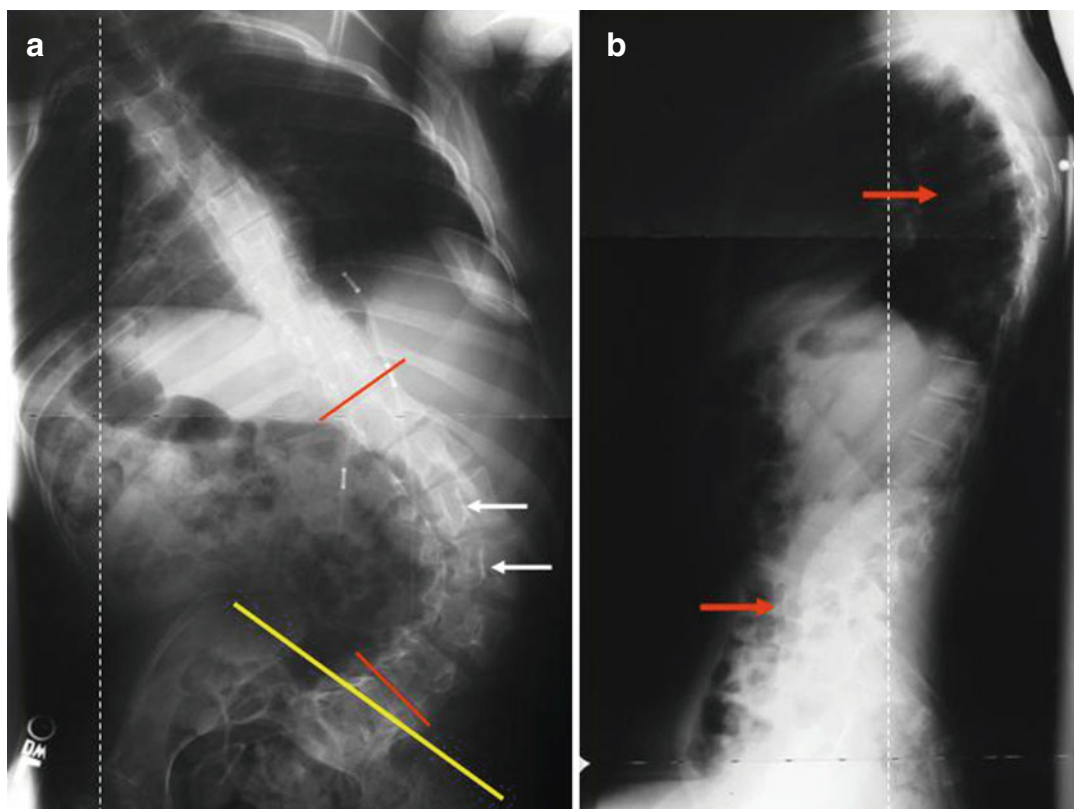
When evaluating a patient with CP scoliosis, there are other radiographic parameters in addition to the Cobb angle (*red lines*). Note the severe apical rotation
